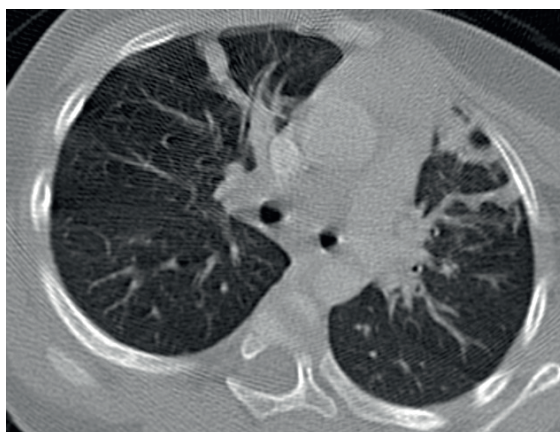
A-1-year-old girl with respiratory syncytial virus-B infection. Axial non-contrast enhanced chest CT image shows subpleural atelectasis in the upper lobes.
